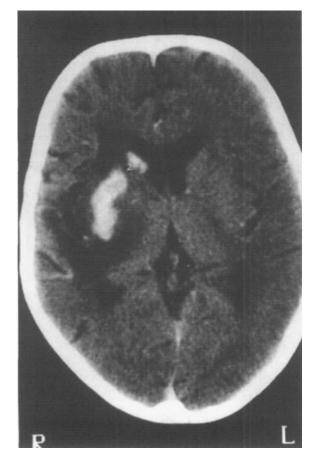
First post-contrast CT scan of the brain showing two enhanced areas of suppurative encephalitis.
